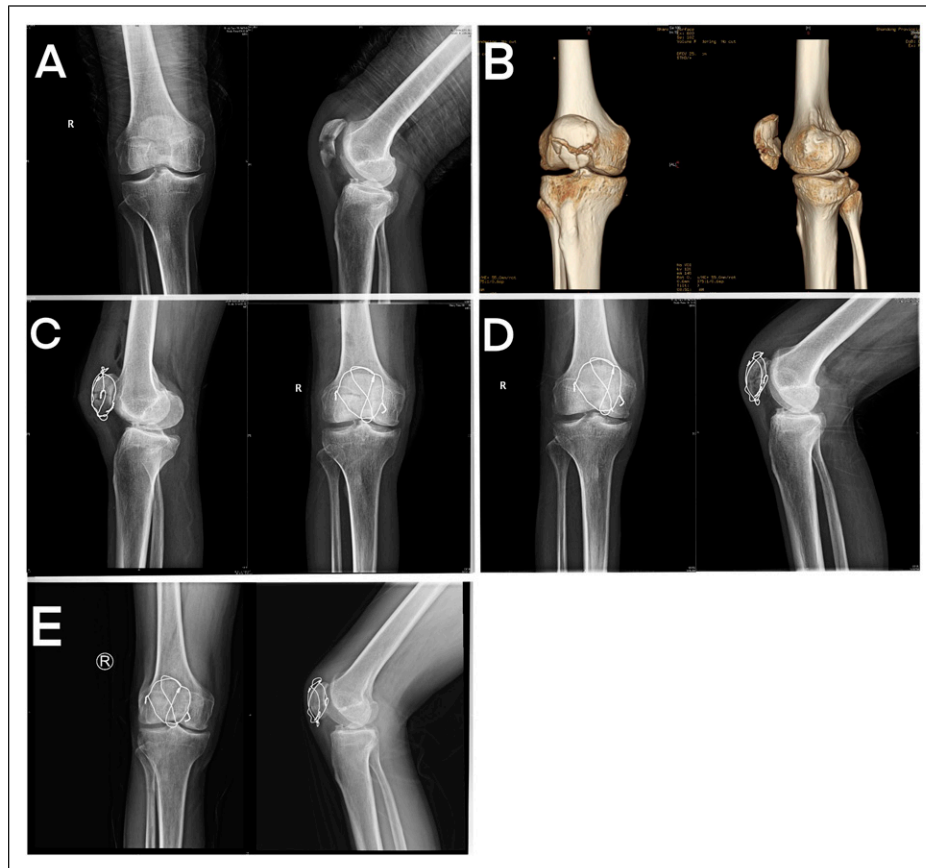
A 66-year-old male with a patellar fracture. (A) X-ray before surgery. (B) CT before surgery. (C) Post-fixation with modified cerclage wiring. (D and E) 3 months and 12 months after surgery.
